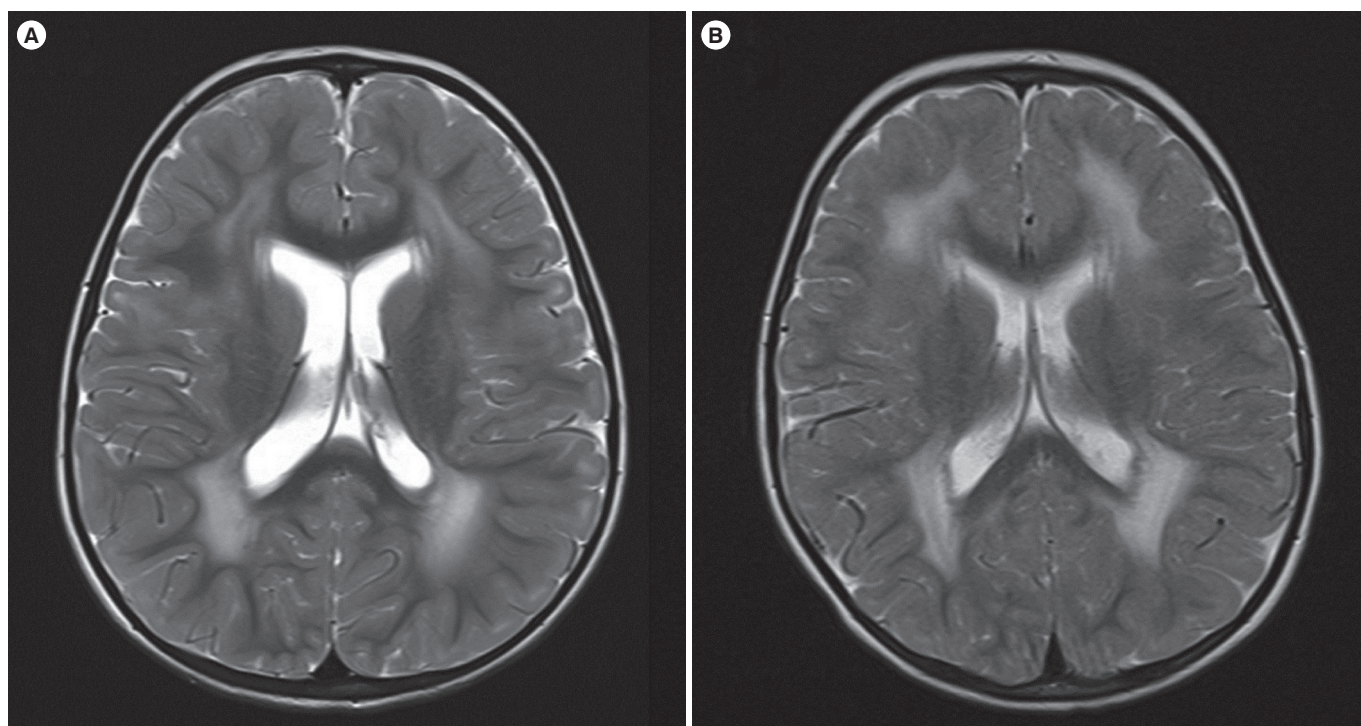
Axial T2-weighted magnetic resonance images (A, the proband; B, the proband's sister) showing diffuse high signal intensity in the bilateral periventricular and subcortical white matter.
